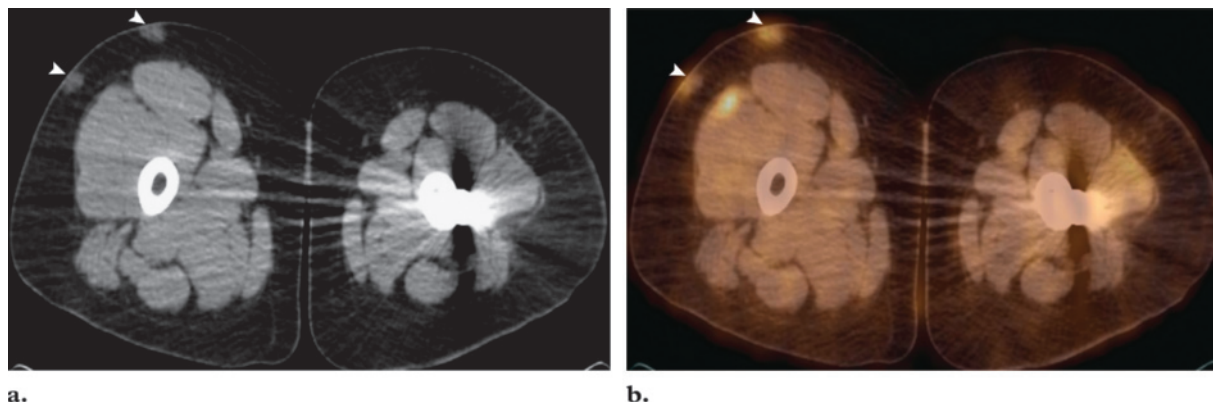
FDG uptake at subcutaneous injection sites in a 16-year-old girl with a history of lymphoma and pathologic fracture of the proximal left femur. The patient had a history of prophylactic subcutaneous injections of low-molecular-weight heparin and had undergone hardware fixation. (a) Transverse CT scan obtained at the level of the thigh shows areas of soft-tissue attenuation (arrowheads). (b) Transverse fused PET/CT image shows foci of subcutaneous uptake (arrowheads) corresponding to the areas of soft-tissue attenuation seen at CT.
